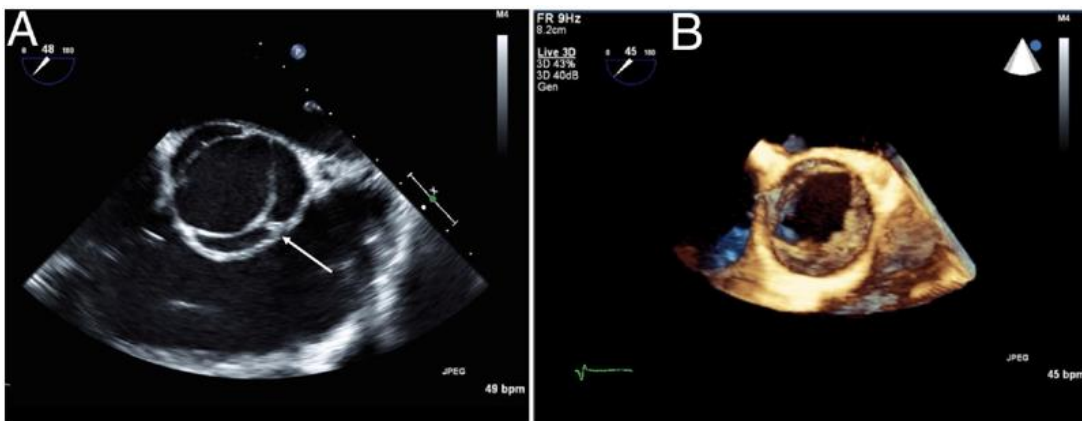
Bicuspid Aortic Valve (BAV). (A) Transesophageal short-axis view of BAV. (B) 3D Transesophageal view of BAV¹⁰.
